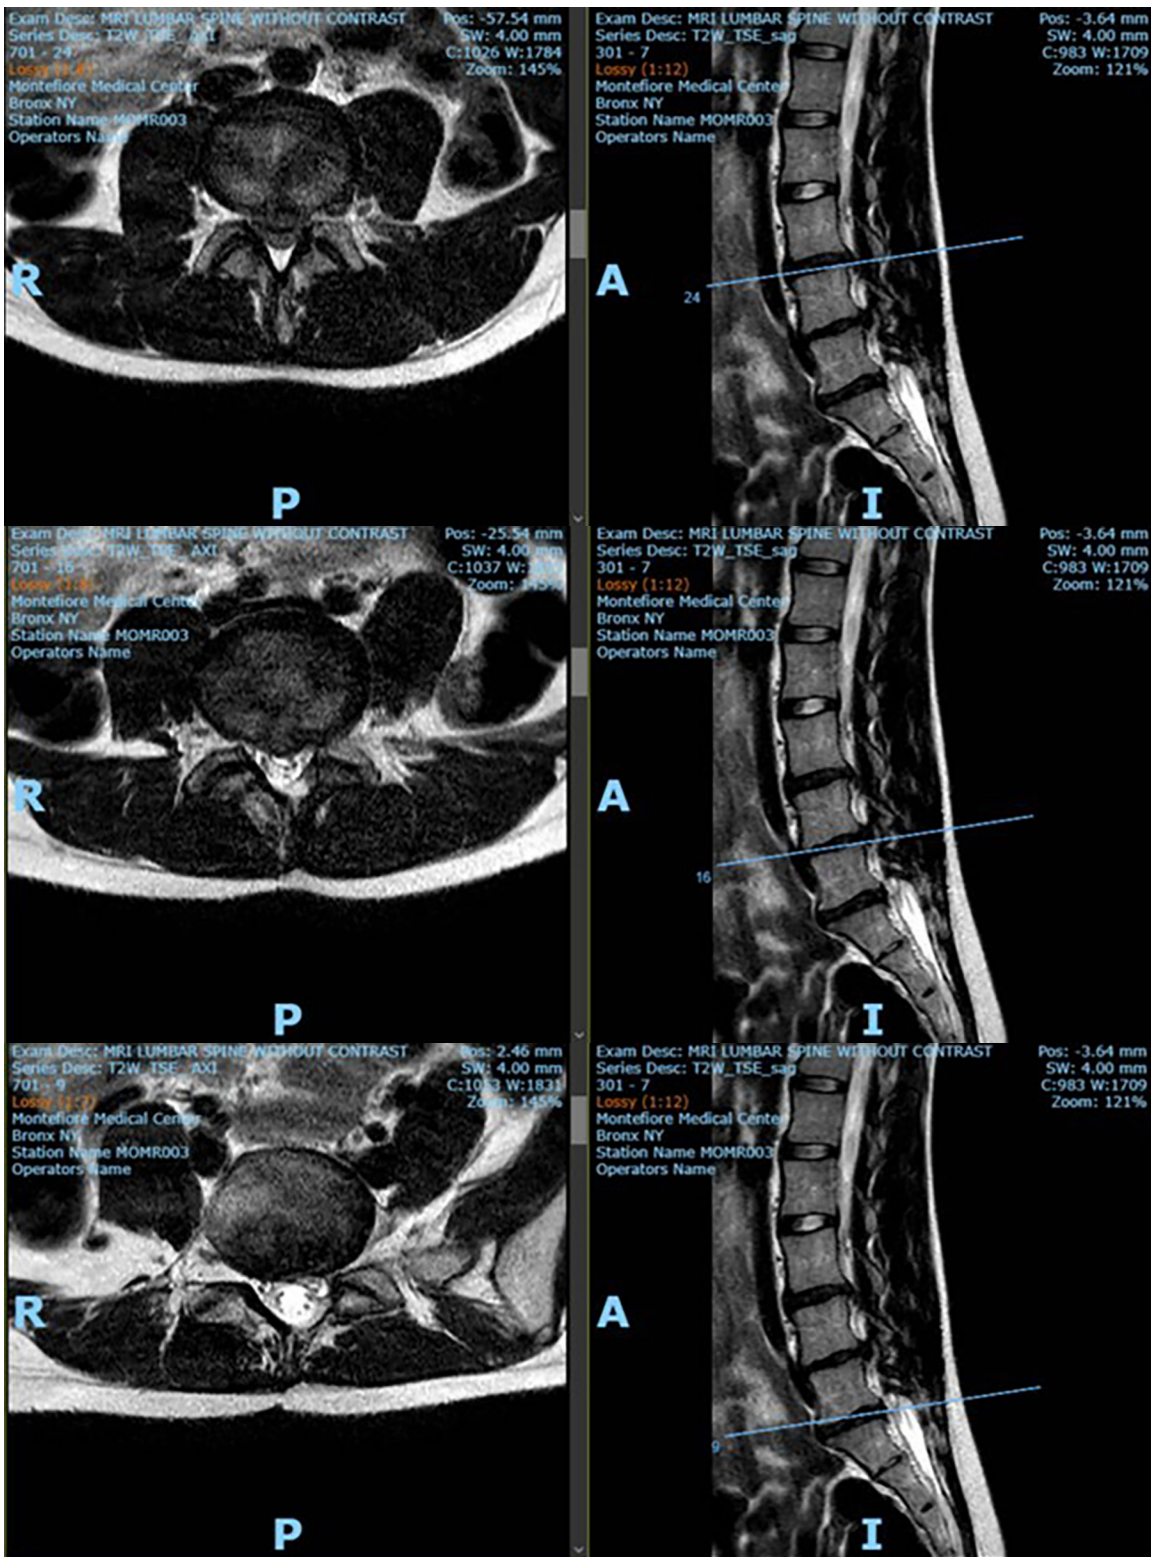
Lumbar MRI from May 2025.
